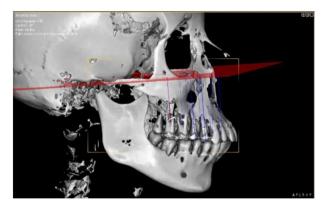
Intrusion measurements on a cone beam computed tomography image: distance from the center of premolars or molar trifurcation to the Frankfurt horizontal plane.
